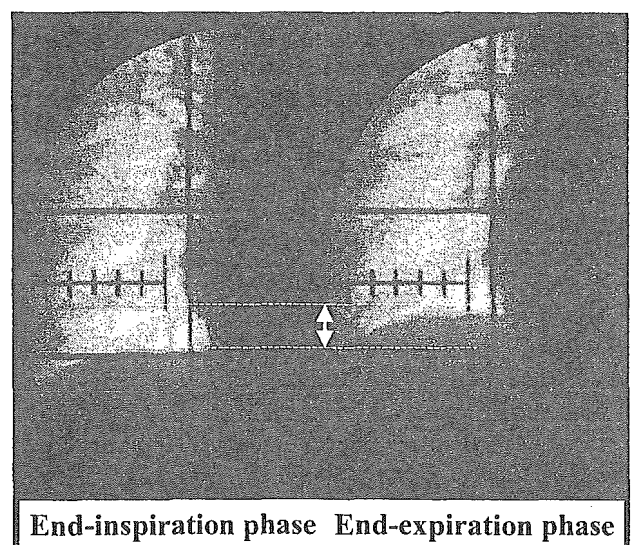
Diaphragm motion distance under free breathing. To measure the diaphragmatic motion from the end-inspiration phase to the end-expiration phase in the CC direction, the volunteers breathed freely under X-ray fluoroscopy.
